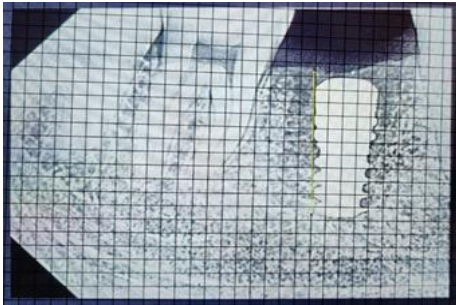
Calibrated grid superimposed on the periapical radiograph using ImageJ software for standardized measurement.
